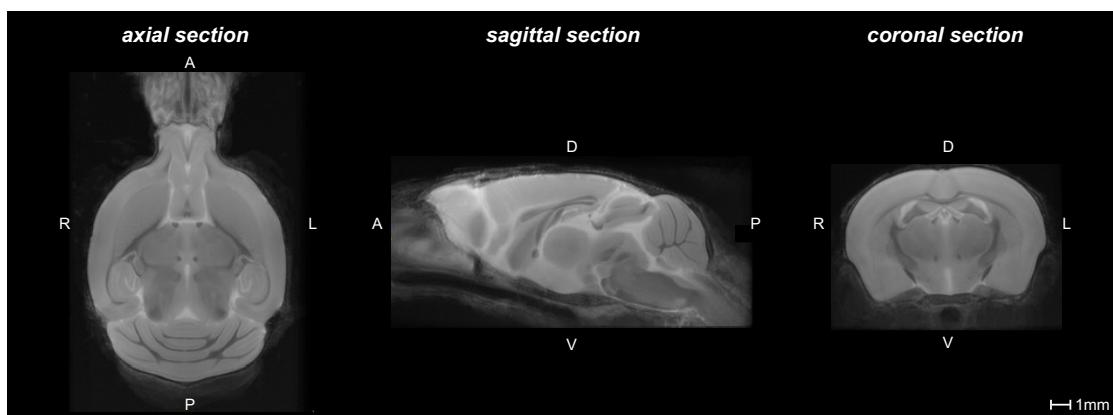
The registered T2-weighted study template. The study template is the average of all study samples that all individual subjects' samples are spatially registered to for the purpose of calculating the Jacobian deformation fields. This study template is based on samples taken one day after a DOI injection. A: anterior. P: posterior. D: dorsal. V: ventral. R: right. L: left.
